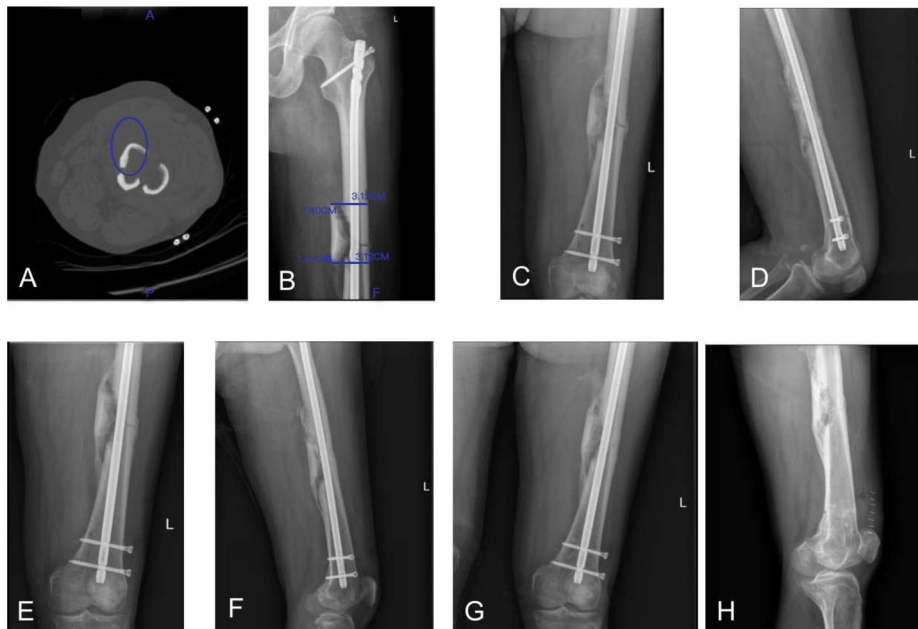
A 52-year-old male patient presented with a right femoral shaft fracture caused by a car accident, classified as degree II displaced with type 2 circumference, which was treated with intramedullary nails 12 days after injury. (A) Preoperative CT tomography showed type 2 circumferential fracture of femoral shaft; (B) postoperative X-ray showed degree II displaced fracture of femoral shaft; (C, D) AP and lateral views of X-ray at 3 months after operation showed clear fracture line between the fracture ends; (E, F) AP and lateral views of X-rays at 6 months after operation showed clear fracture line between the fracture ends; (G) AP view of X-ray at 18 months after operation showed clear fracture line between the fracture ends, which did not reach the standard of healing; (H) AP view of X-ray at 43 months after operation showed blurred fracture line at the fracture ends, with bridging callus production, which had reached the healing criteria.
